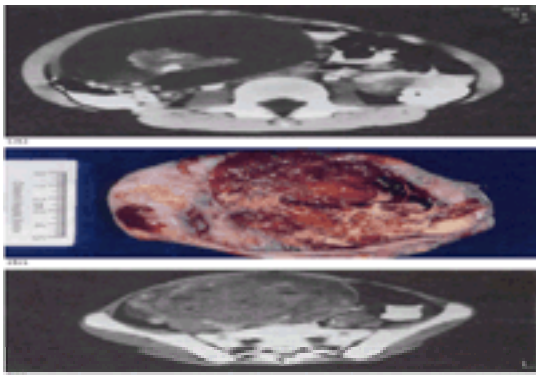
(a) CT scan of a 5-year-old girl who presented with increasing abdominal girth noted by her father showed a primarily cystic tumor with a solid component with calcification. Pathology revealed a mature teratoma with various tissue types present (b). (c) CT scan of an 8-year-old girl with similar complaints reveals a primarily solid ovarian mass, also a mature teratoma.
